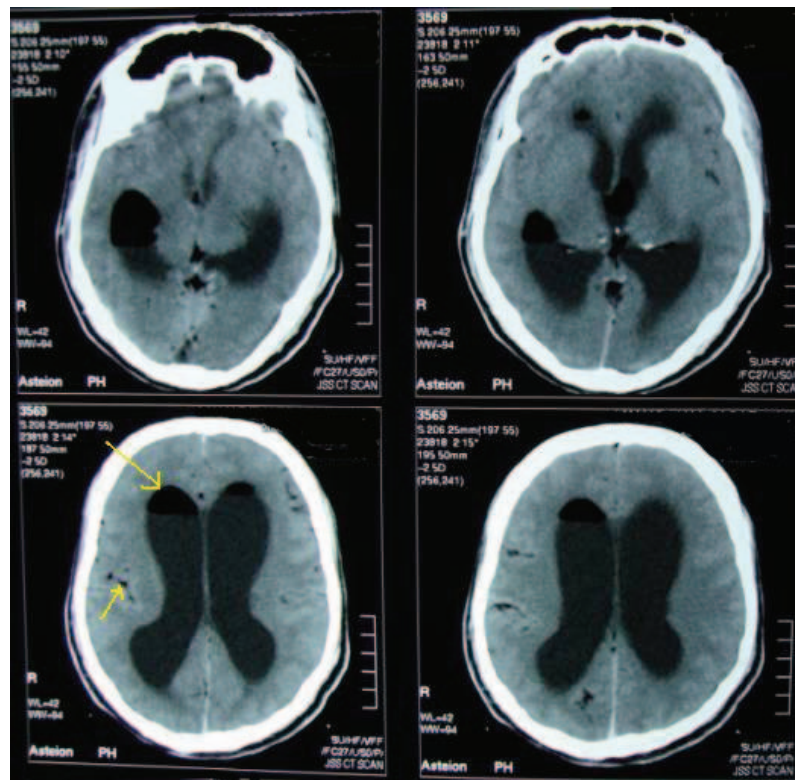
Computed tomography (CT) scan of the brain. Arrows show moderate dilatation of lateral ventricles with intraventricular air pockets as well as small bilateral intracranial air pockets in the sulci.
